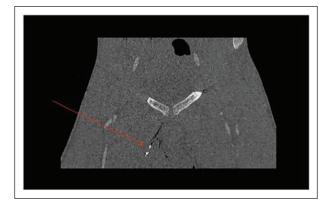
A coronal computed tomographic angiography image is provided, which showed evidence of a small bone fragment located within the scrotum (indicated with a red arrow).
